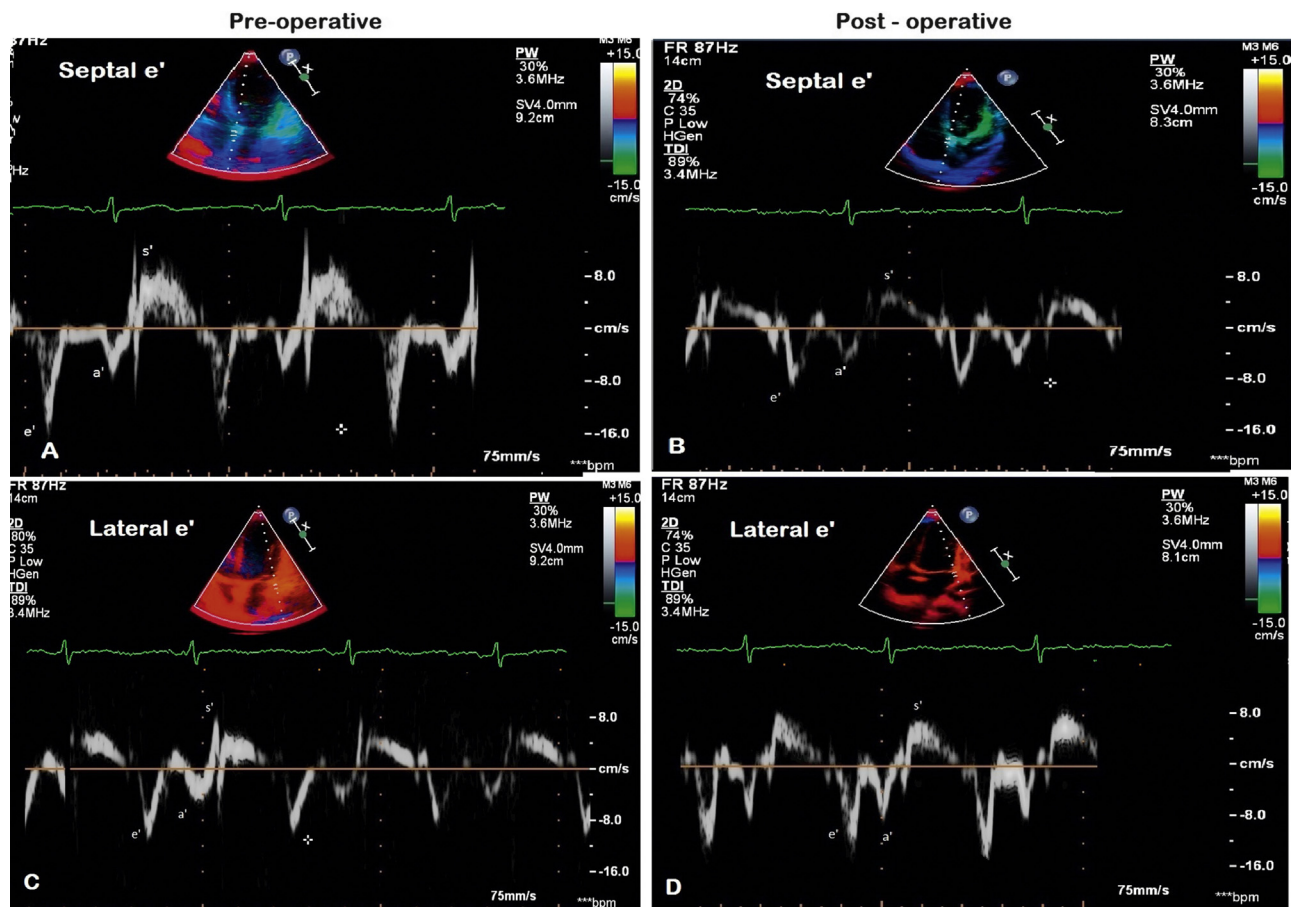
Image of Doppler signals using Tissue Doppler Imaging (TDI) in apical 4-chamber view with 2–4 mm sample volume placed at the septal corner along the mitral annular plane of a patient showing (A) pre-operative and (B) post-operative change in early diastole (e') velocities (septal e'). Similarly TDI at lateral corner along the mitral annular plane in the same patient shows improvement in early diastole (e') velocities (lateral e') (D) post-operatively as compared to the (C) pre-operative image. As the septal e' is larger than lateral e', the phenomenon of 'annulus reversus' is also demonstrated in the pre-operative images.
